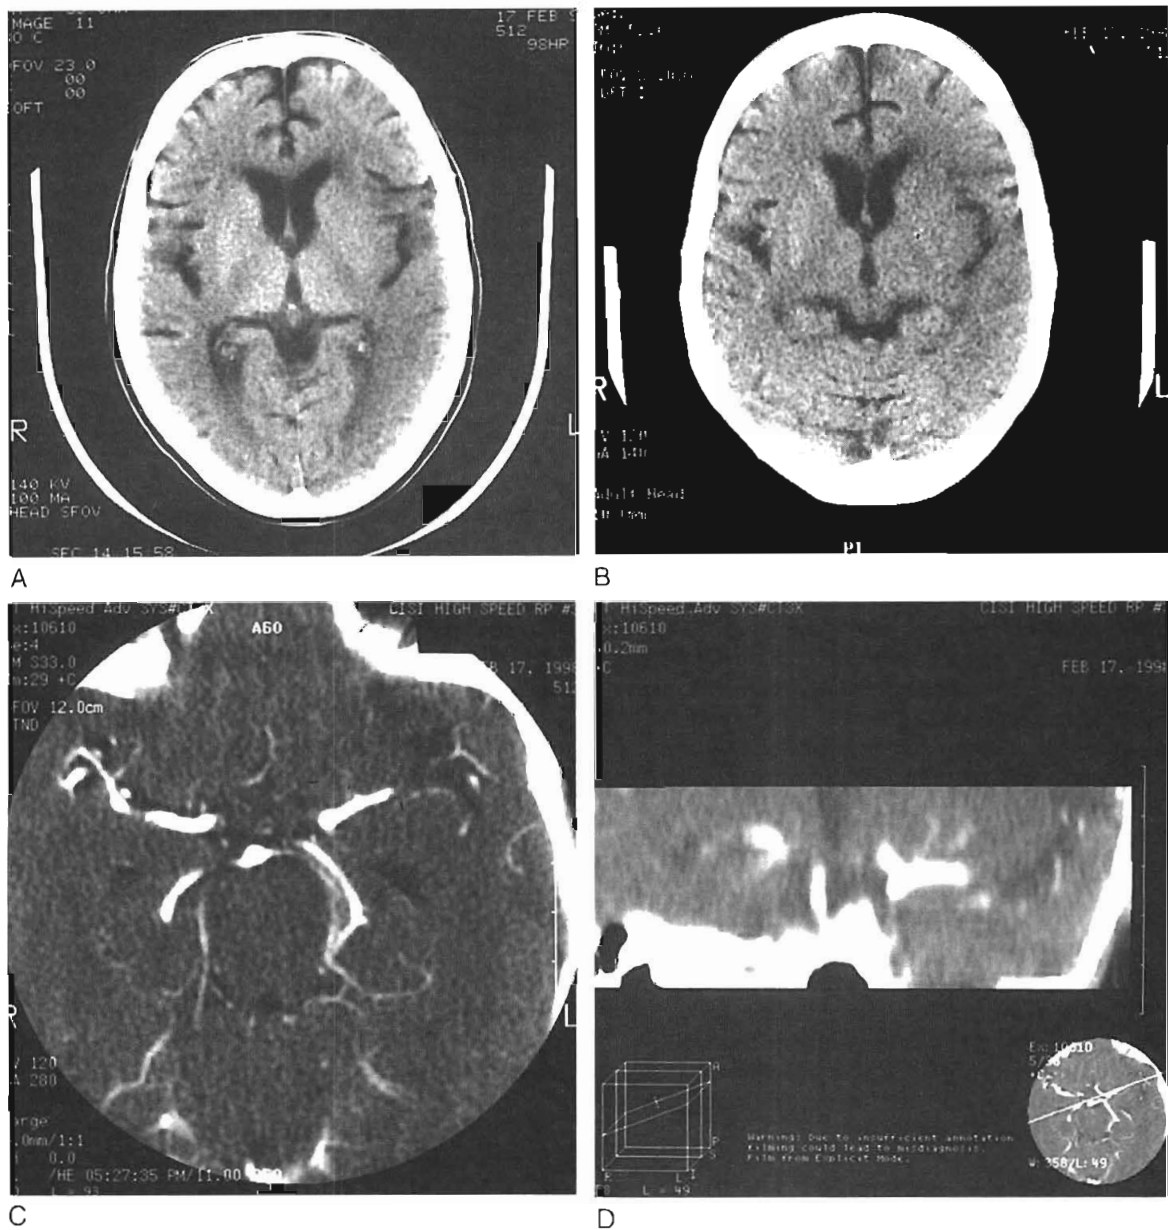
A, Normal computed tomography (CT) scan of brain 2 hours after onset of aphasia and left hemiparesis. B, Repeat CT scan at 5 hours after stroke onset shows early CT changes, including basal ganglia hypodensity, loss of the insular ribbon, and slight effacement of the sulci on the left. C, CT angiogram at 5 hours after stroke onset shows complete occlusion of the left middle cerebral artery. D, Rapid reconstruction of the CT angiogram again shows occlusion of the left middle cerebral artery.
